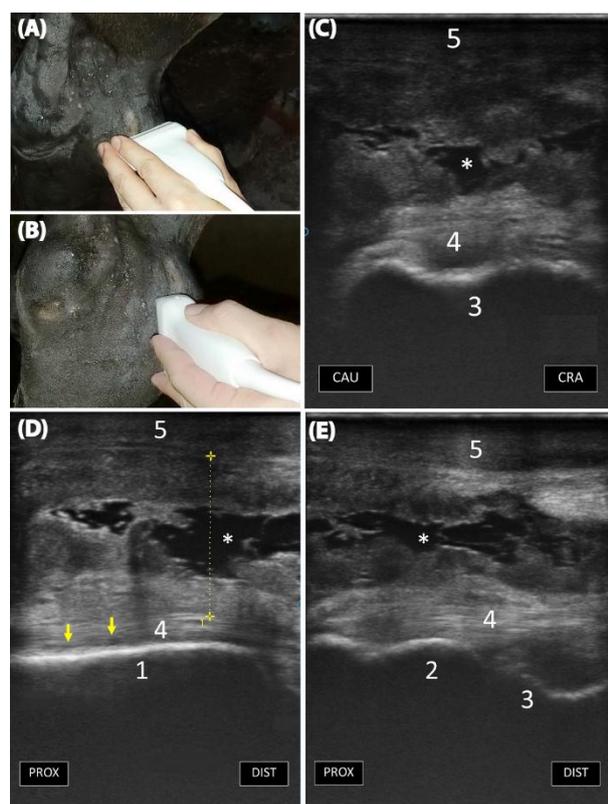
The ultrasonography was performed at the transverse (A) and longitudinal planes (B). The transverse (C) and longitudinal (D and E) ultrasonographic images demonstrate the hypoechoic soft tissue swelling and synovial thickening with anechoic effusion (*). The images also show a small loss of normal fibre pattern in the lateral extensor tendon (yellow arrows) (D). Synovial proliferation is seen at the inner lining of the affected tendon sheath (D and E). The width of the thickened synovial tendon sheath at the most distended point was 2.33 cm (yellow vertical dots) (D). PROX = proximal part; DIST = distal part; CAU = caudal part; CRA = cranial part; 1 = tibia; 2 = tibial malleolus; 3 = talus; 4 = lateral extensor tendon; 5 = skin; asterisk (*) = anechoic fluid.
